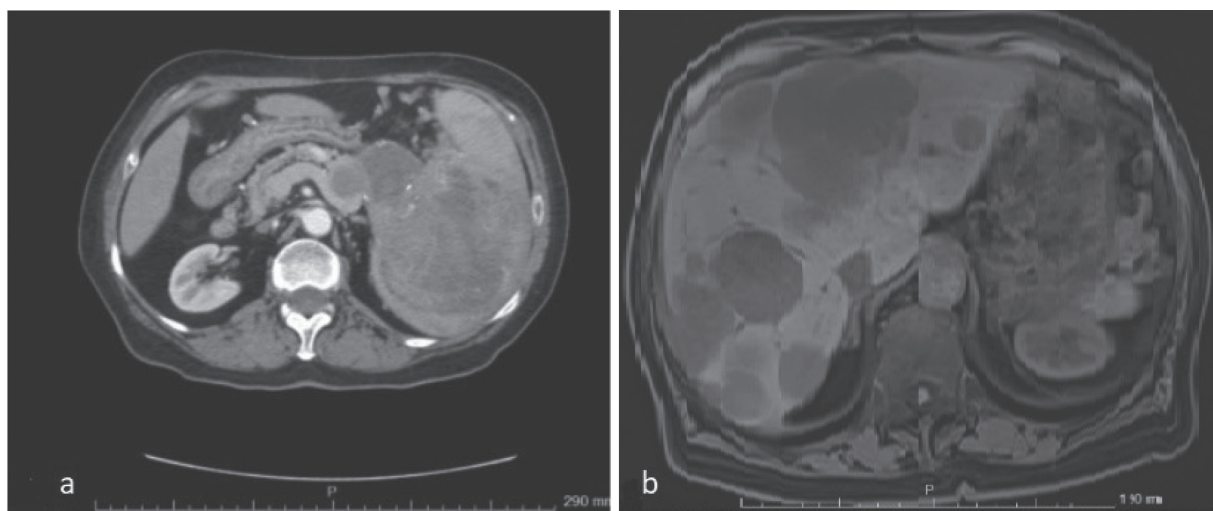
Preoperative CT imaging, revealing a solid pseudopapillary pancreatic tumor (a) and postoperative MRI, revealing metastatic liver lesions (b)
